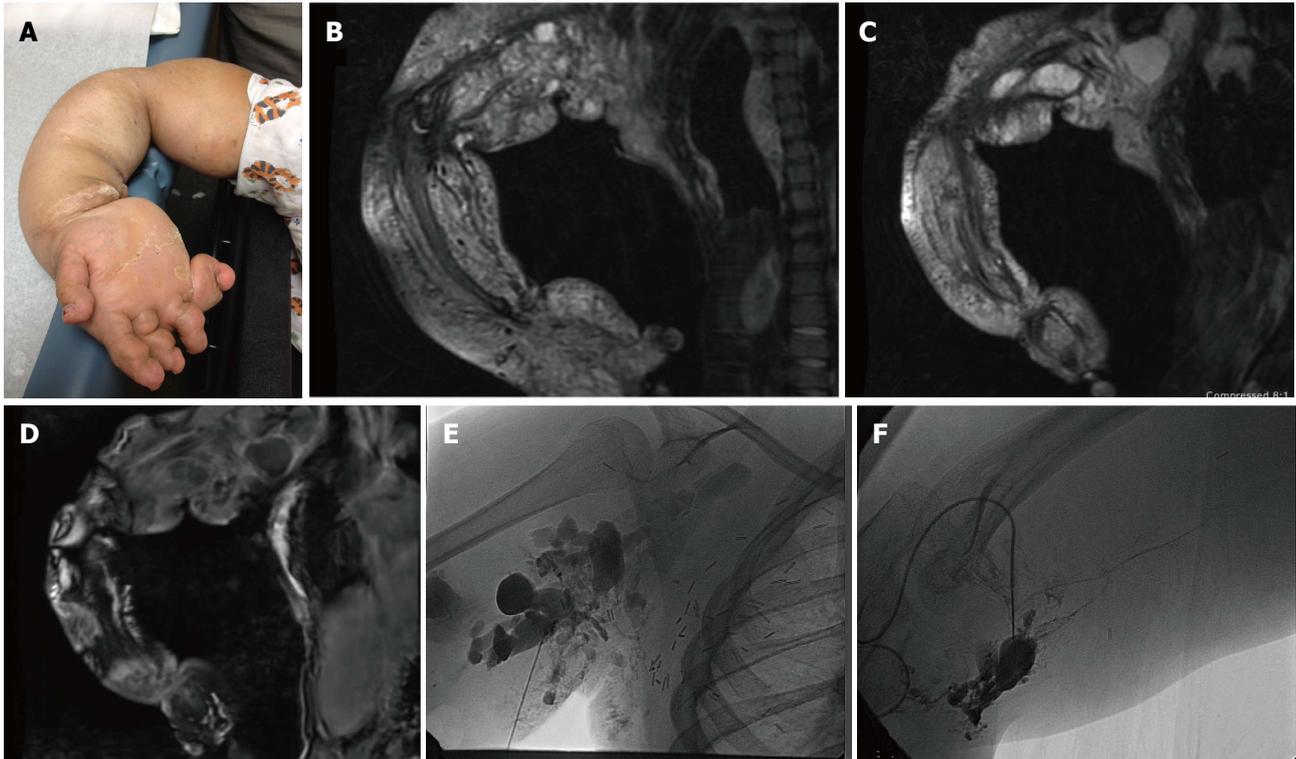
Ten-year-old girl with CLOVES syndrome. Photograph (A) demonstrates right upper extremity overgrowth. Pre-treatment coronal MR images of the right upper extremity (B, C, D) demonstrate a large, combined macro/microcystic lymphatic malformation with venous lakes in the axilla and evidence of lipomatous overgrowth. Angiographic images (E, F) demonstrate direct puncture of the malformation followed by sclerosis with doxycycline.
